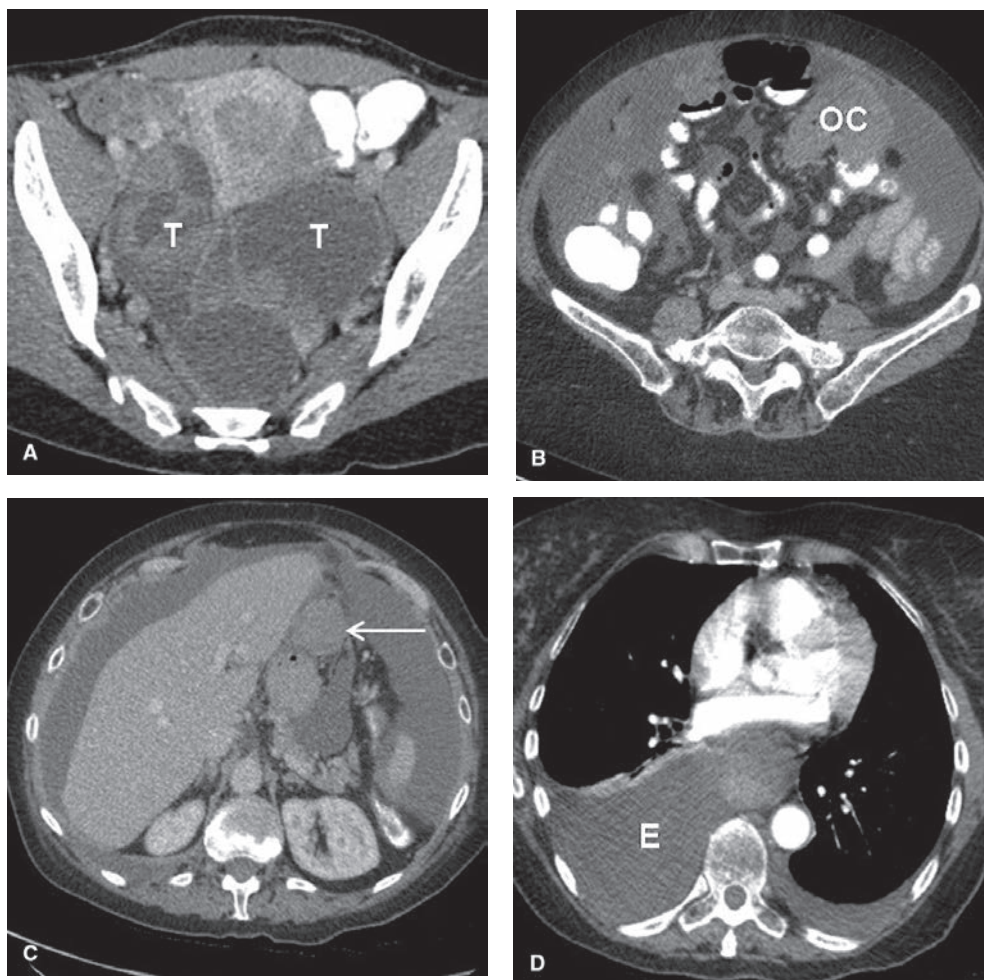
Ovarian carcinoma. Axial contrast-enhanced CT images demonstrate bilateral complex cystic and solid adnexal lesions (T in A), omental cake (OC in B), a peritoneal deposit in the gastrohepatic ligament (arrow in C), as well as ascites and bilateral pleural effusions largest on the right (E in D).
